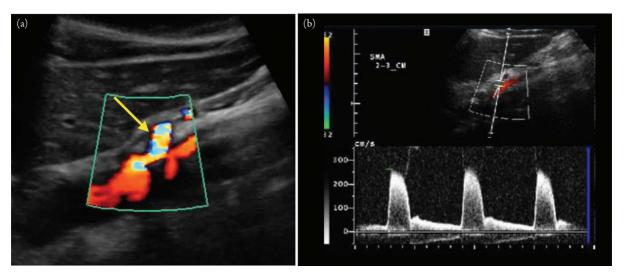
(a) Longitudinal axis view of the aorta with the superior mesenteric artery (SMA) take-off. Color Doppler reveals some aliasing that is suggestive of SMA stenosis and mesenteric ischemia. When this is suggested, pulsed-wave Doppler should be used to evaluate the peak systolic velocity of the SMA to determine the presence of stenosis. (b) Spectral waveform of celiac and superior mesenteric arteries, with normal ranges for peak systolic velocity.
